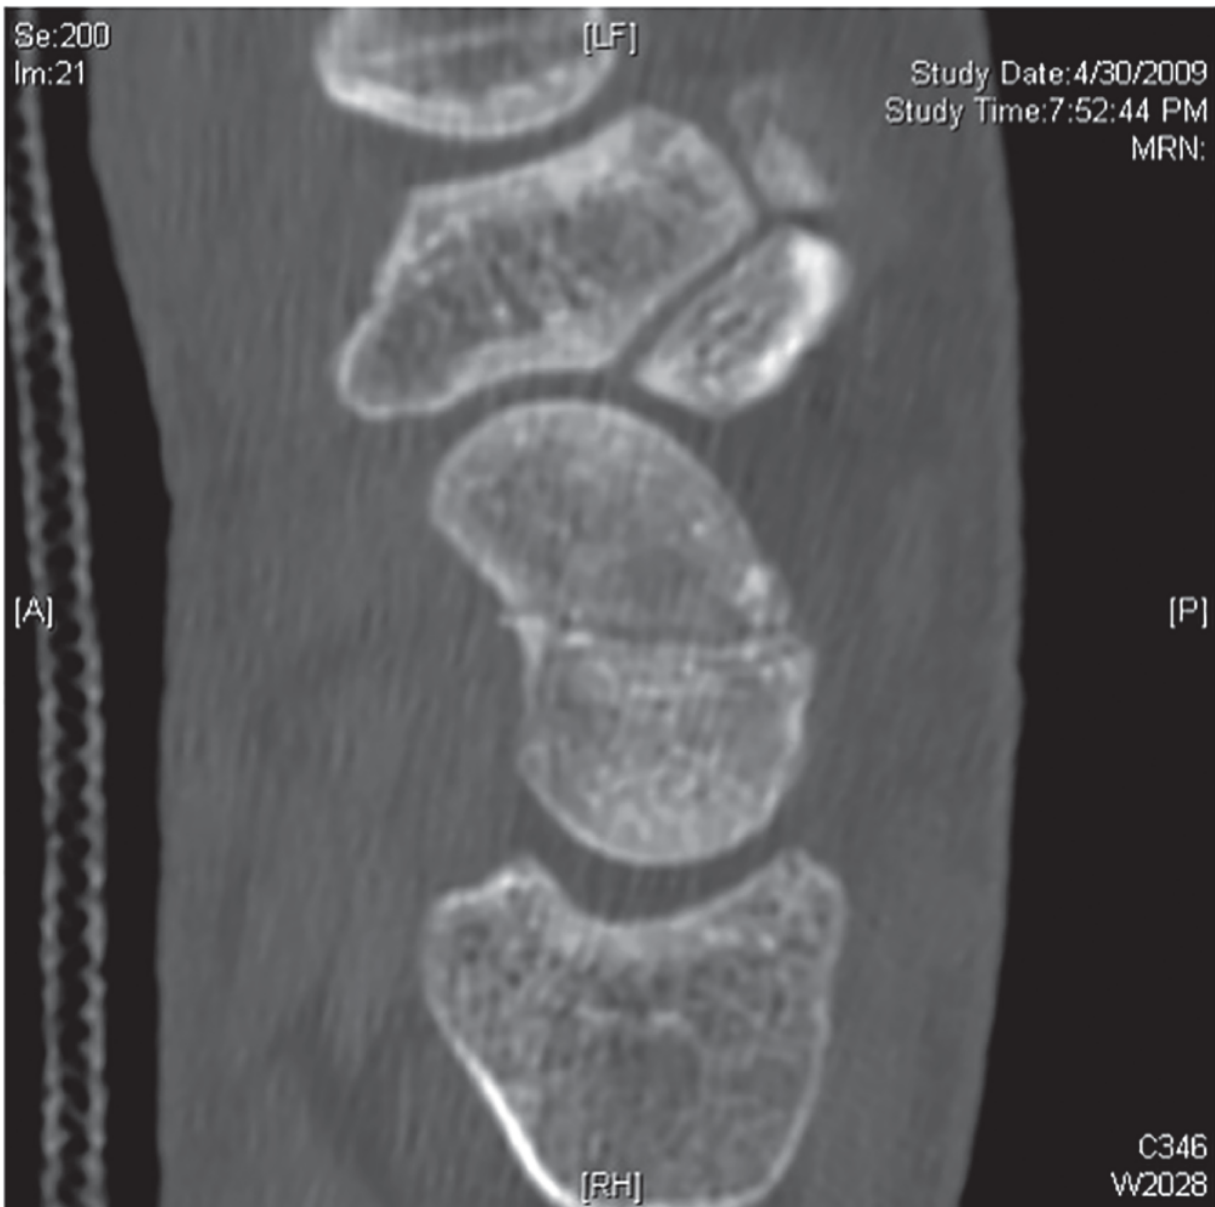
CT scan of the same patient in [Figure 89.1](#). CT can identify occult fracture but is more useful in assessing fracture displacement and angulation.
